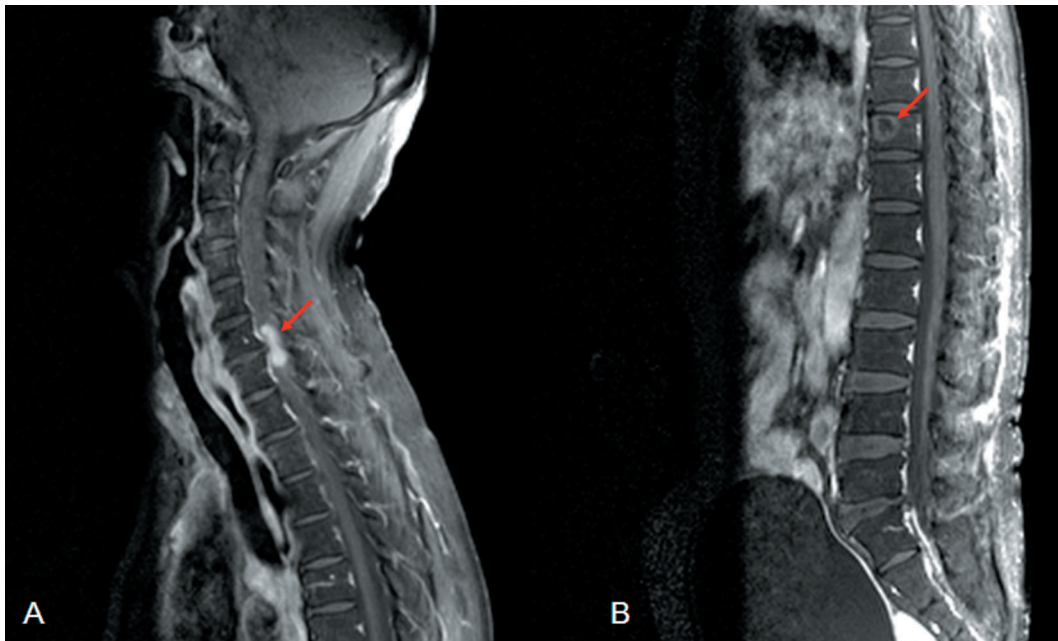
The spinal MRI in Gadolinium-enhanced T1 weighted image showed an intramedullary enhanced lesion (arrow) in the C6~C7 region (A) and multiple well-defined lytic lesions with sclerotic margins and ring form enhanced vertebral lesions at the lumbar spines (B), indicating vertebral sarcoidosis.
